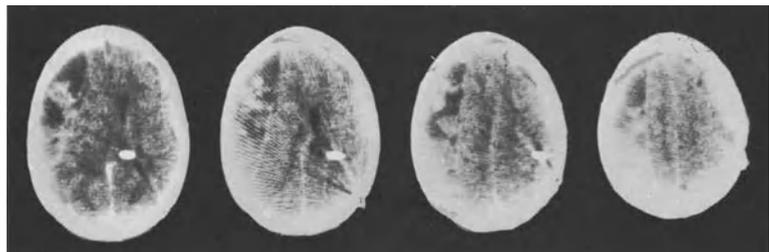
a-d. CT observations before (a) and after (b-d) surgical evacuation of a space-occupying chronic subdural haematoma. CSF-drainage was instituted 3 years ago
